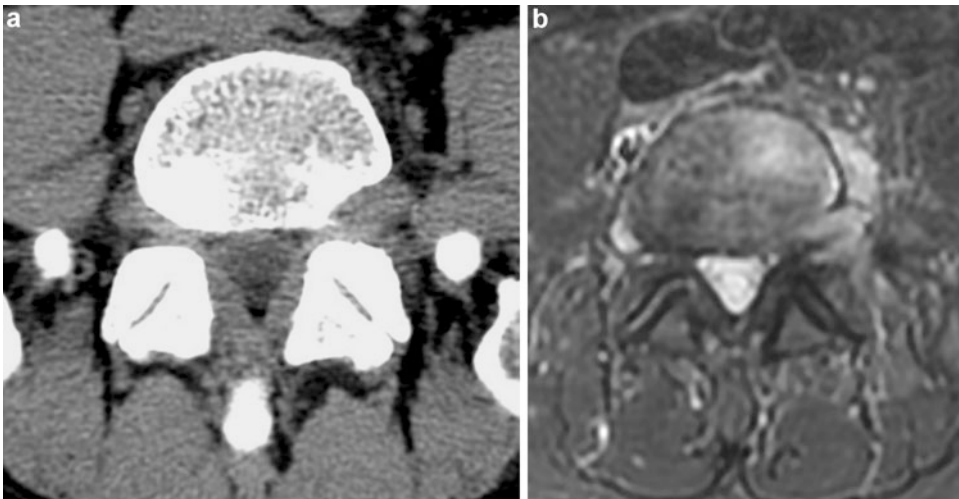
(a) CT axial image through L5-S1 foramina showing a left intraforaminal hyperdense mass associated to disappearance of intraforaminal fat, compression of ganglion, and scalloping of left posterolateral vertebral body.
